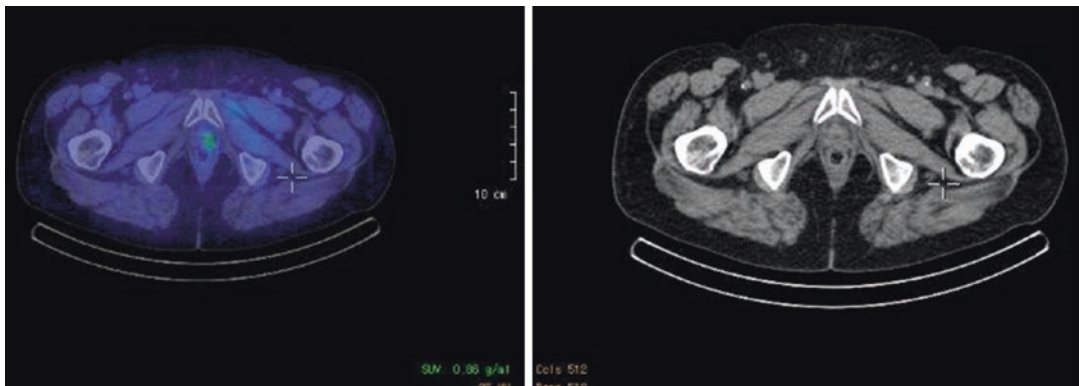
¹⁸F-Fluciclovine PET/CT had been helpful to identify a local relapse of prostate cancer—due to the fact that there is no relevant uptake of this tracer in urine
